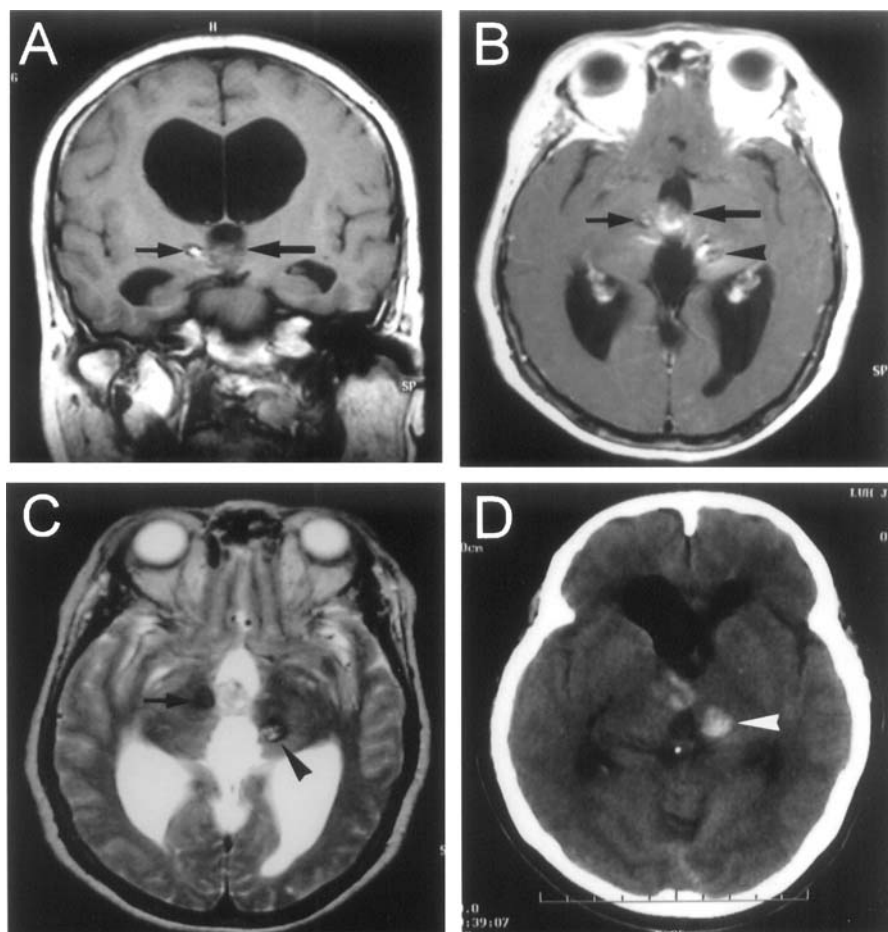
Magnetic resonance imaging (MRI) of the intracerebral, deep-seated cavernomas. (A) Coronal section of T1 weighted MRI shows an iso-intense tumour located in the third ventricle (large arrow), and a lesion in the right side of the hypothalamus with a hyperintense center surrounded by hypo-intense signal rim (small arrow). The third and lateral ventricles are dilated. (B) Axial section of gadolinium-enhanced T1 weighted MRI reveals enhancement of the third ventricle tumour (large arrow) and another two tumours located in the right side of the hypothalamus (small arrow) and the left thalamus (arrowhead). There is also a linear lesion at the hypothalamus. (C) Axial section of T1 weighted MRI shows two tumours located in the right side of the hypothalamus (small arrow) and the left thalamus (arrowhead). These tumours show mixed-signals, reticulated cores surrounded by hypo-intense-signal rims. (D) Unenhanced computed tomographic imaging 3 days after excision of the third ventricle tumour reveals an intracerebral haematoma in the left thalamus (arrowhead) and a small haematoma within the third ventricle
